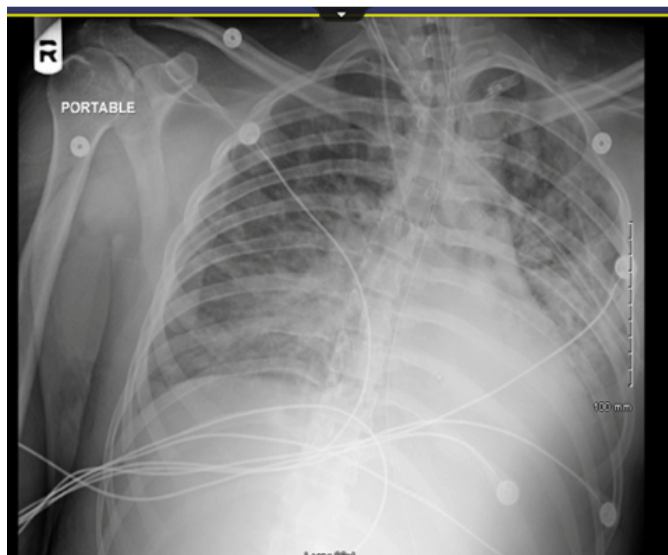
Chest X-ray less than 24 hours after administration of methylprednisolone.
